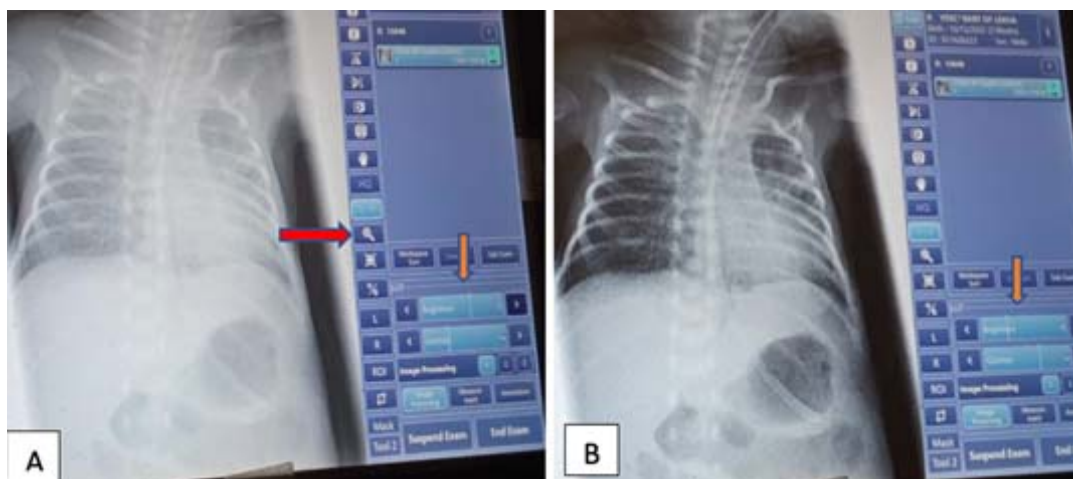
Post-exposure, digital picture enhancement techniques. (A) Magnification changes are possible (red arrow), X-ray is at lesser contrast setting and higher brightness (black arrow), (B) easily visualised endotracheal tube, orogastric tube with less “noise” and sharper picture quality by change in settings (white arrow).
